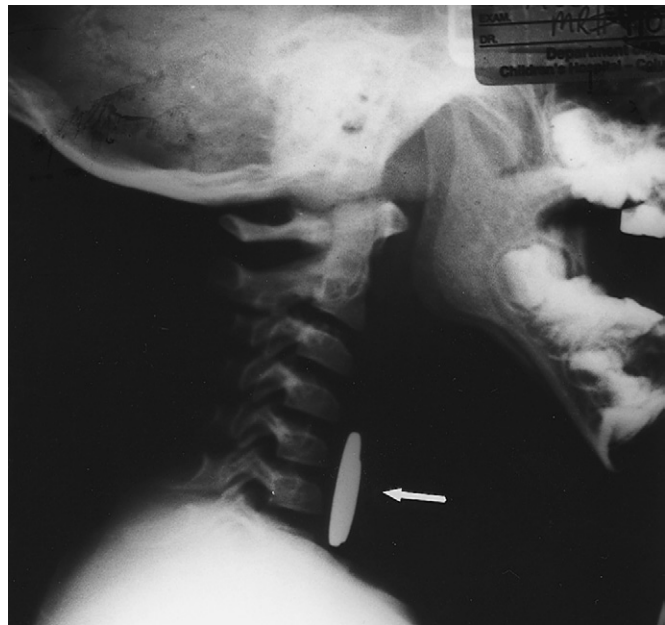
Lateral neck x-ray film of a child presenting with gagging and drooling, showing two coins (arrow) in the esophagus near the cricopharyngeal junction.
